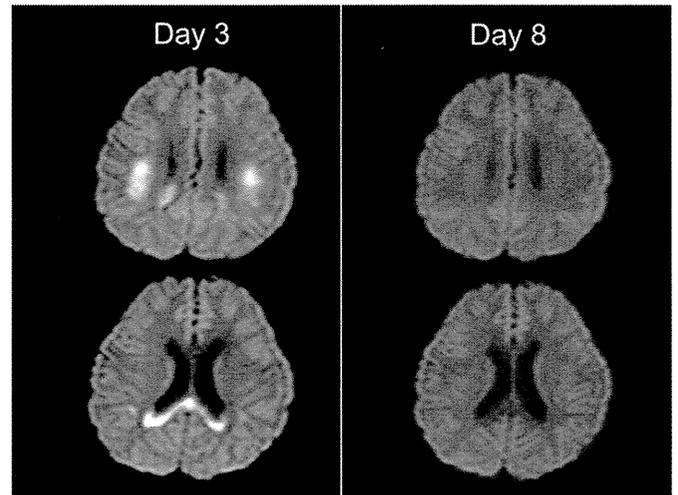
MRI of patient 2. On day 3, diffusion-weighted images reveal lesions in the splenium of the corpus callosum and symmetric white matter. These lesions disappear completely on day 8, which is compatible with MERS type 2.
